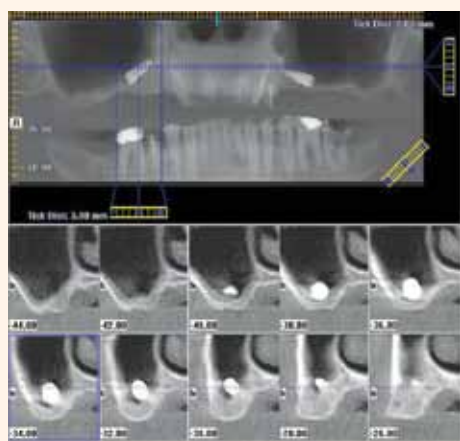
Pre-operative diagnostic cone-beam CT revealing, among other things, two implants displaced into the right and left maxillary sinuses. By utilizing the i-CAT™ 3D CBCT (Imaging Sciences International, Hatfield, Pa.), which includes clear-cut panoramic and cross-sectional slices of any desired location, one obtains precise anatomical information.
